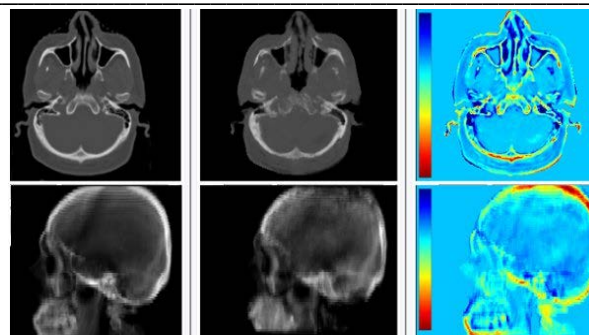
Top -From left to right: Transverse slice of CT, pseudo-CT, difference map
